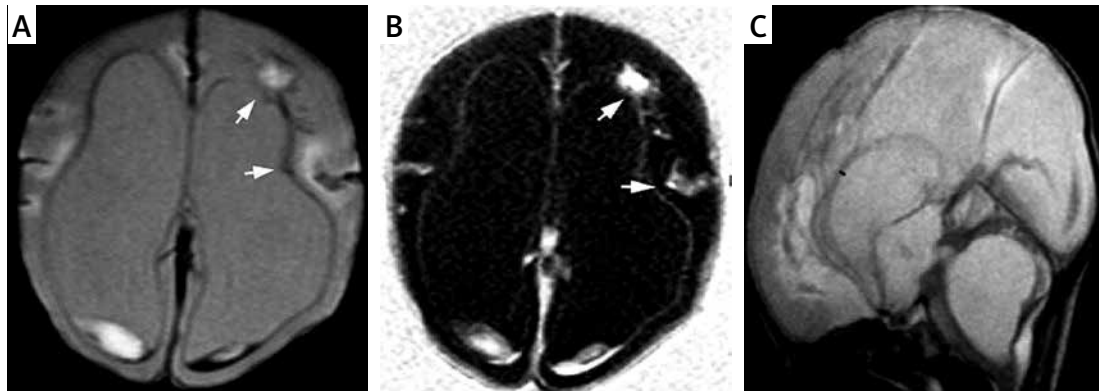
In the first patient, axial T2-weighted (A) and T1-weighted (B) images show progressive cortical and white matter atrophy. Subependymal T1-hyperintense and T2-hypointense areas (arrow) and ventriculomegaly congruent with germinal matrix grade 3 hemorrhage are observed. In the sagittal T2-weighted images (C) the hypoplasia of the corpus callosum and cystic dilatation of the fourth ventricular are clearly visible
